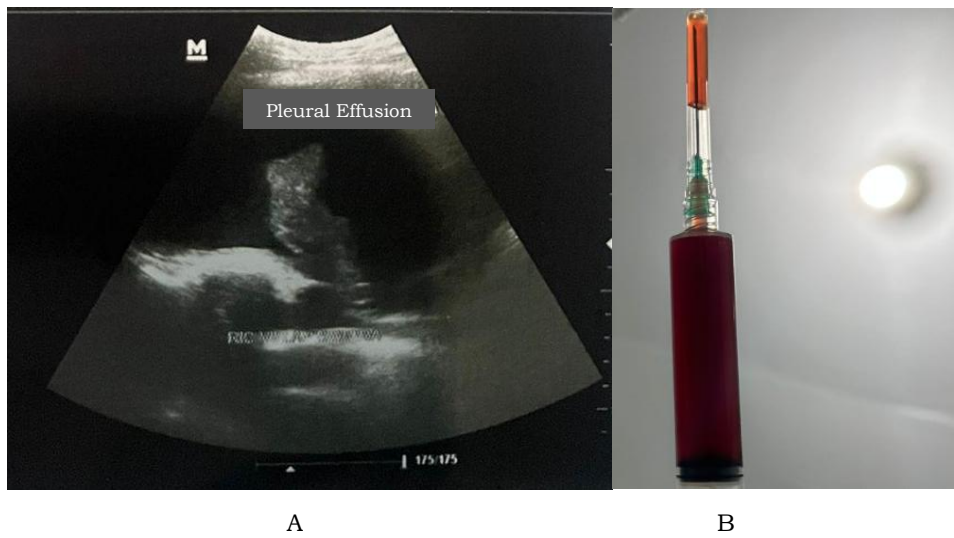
A. Thoracic ultrasonography with the impression of pleural effusion. B. Proof of pleural fluid with a brownish-red color.
